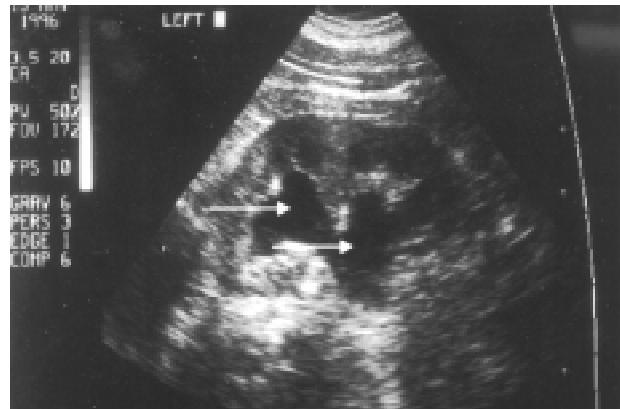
Renal ultrasound reveals dilation of the renal pelvis and calyces (arrows).
